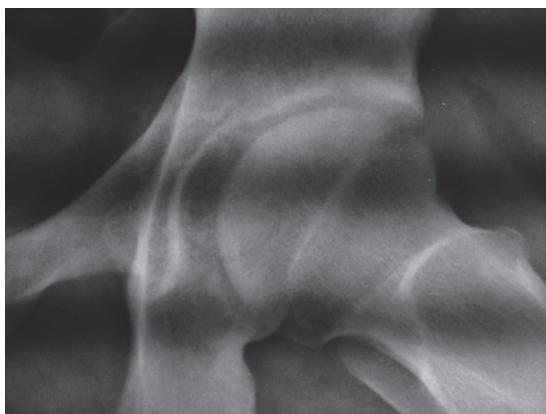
Standard hip radiograph showing no pathological features.
